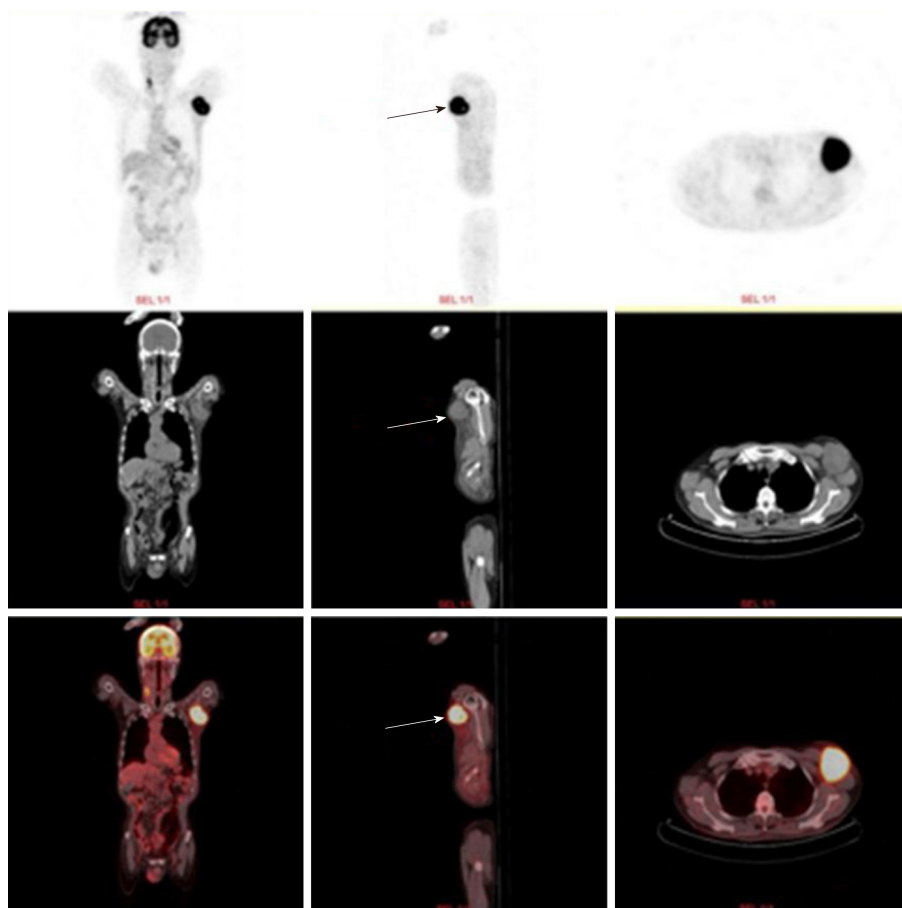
Positron emission tomography computed tomography examination showed that a 6.2 cm × 5.5 cm soft tissue mass was visible in the left axilla (arrow).
